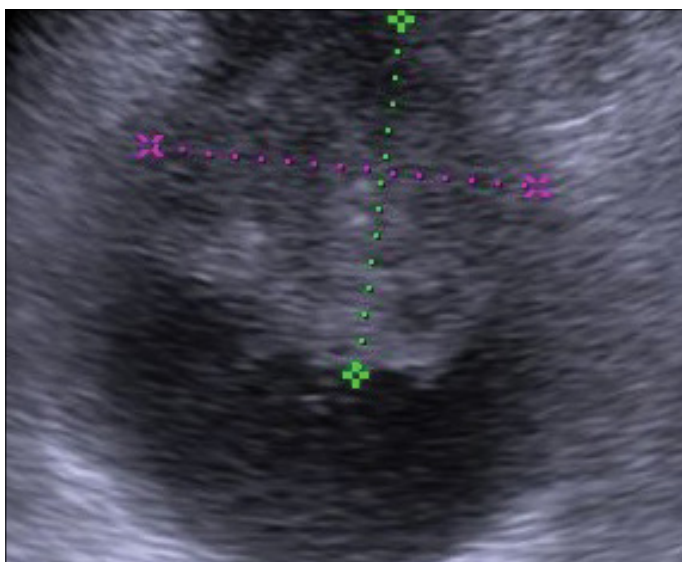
Hematoma in the bladder on ultrasound image
